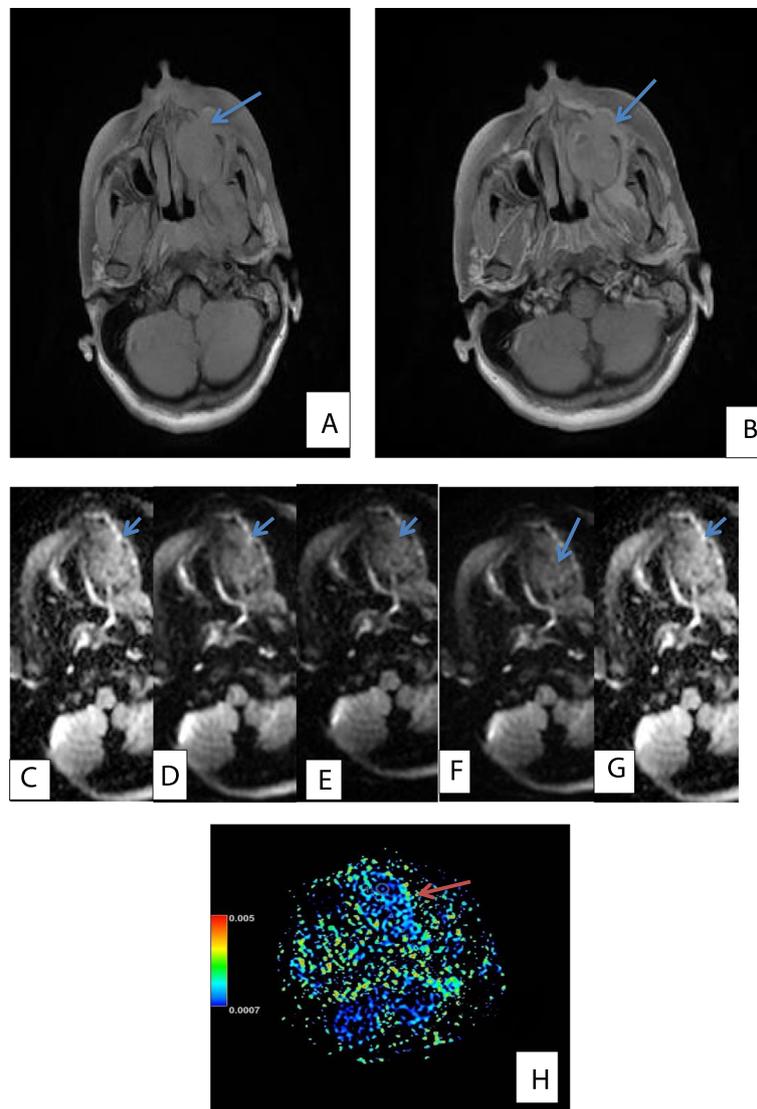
Thirty- five-year-old female patient with adenoid cystic carcinoma of salivary gland centered upon the left maxillary sinus. a Axial T1. b Axial T1 + C. c–g Axial diffusion-weighted imaging with b values: 50, 400, 800, and 1000 respectively, h) ADC map, it displayed low signal intensity in T1, with homogeneous enhancement after IV contrast, while the cystic parts show no enhancement. The lesion elicited high signal intensity in DWI, in both low and high b values (cystic areas are excluded) with corresponding low signal intensity in ADC map (restricted diffusion), ADC value = 0.77×10^{-3} s/mm² (low)
